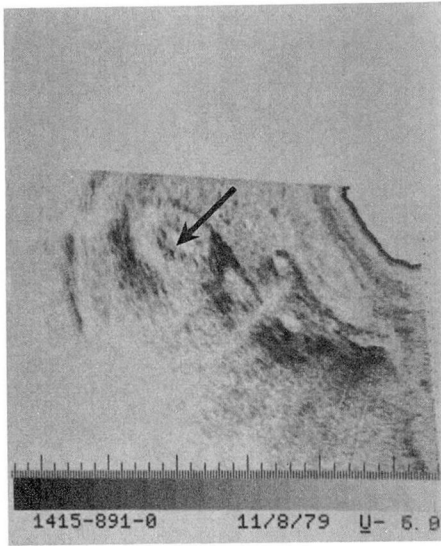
(top) and B. (bottom) Transverse and longitudinal ultrasonograms of a normal kidney in a patient who was hydrated as part of a pelvic ultrasonic study. Note the dilated renal pelvis as manifested by the clear area of separation of the renal hilar echoes (arrow). This may be easily mistaken for hydronephrosis. Intravenous pyelogram was normal.
